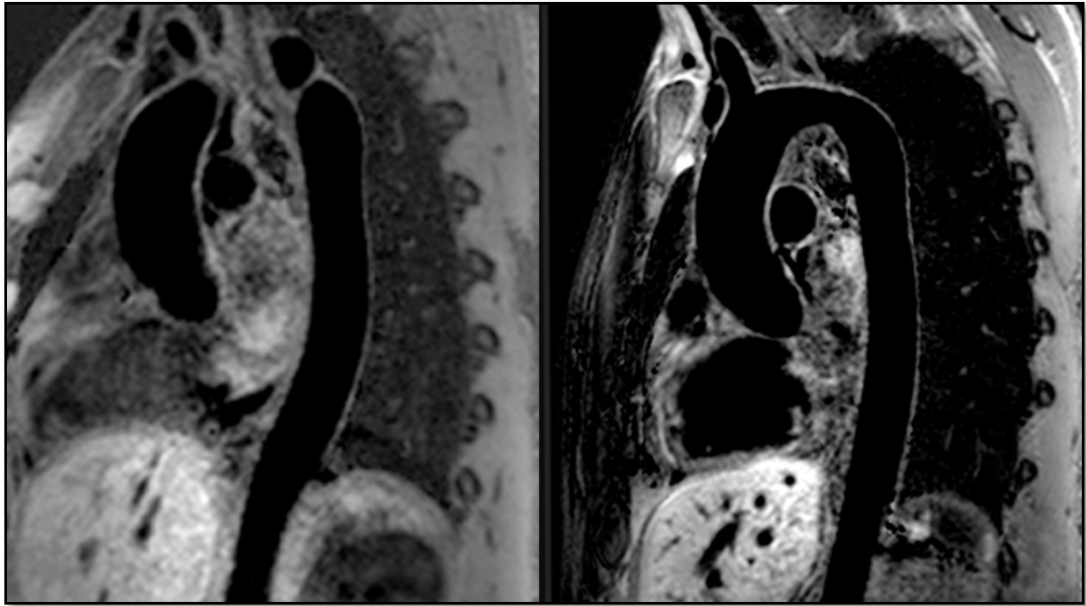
WITH BLACK BLOOD MRI TECHNIQUES THE VESSEL WALL APPEARS BRIGHT AND BLOOD BLACK. THIS ALLOWS FOR CLEARER VISUALIZATION OF VESSEL WALL PATHOLOGY. THESE IMAGES ARE FROM HEALTHY VOLUNTEERS.
